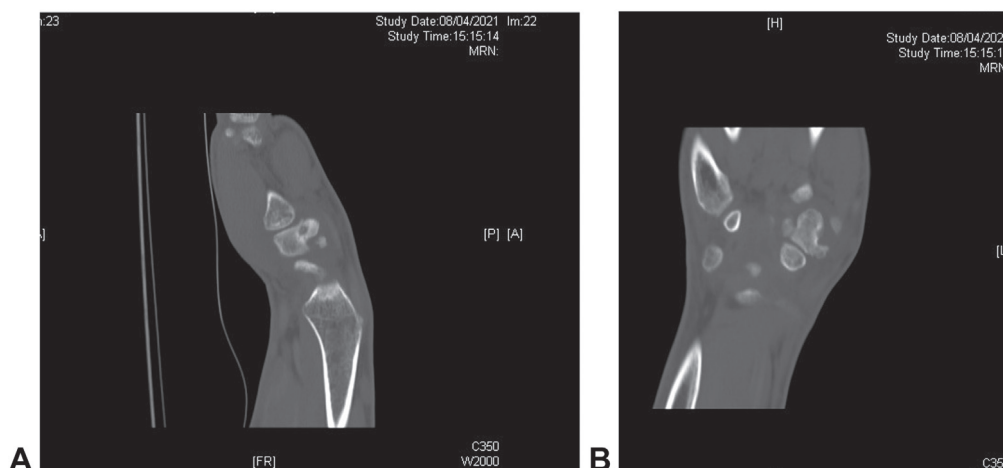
Computed tomography performed before surgery. The erosive aspect of the lesion in A longitudinal view and the nidus and sclerotic perilesional area in the B sagittal view are shown. The CT examination is the most accurate imaging examination for suspecting osteoid osteoma.
